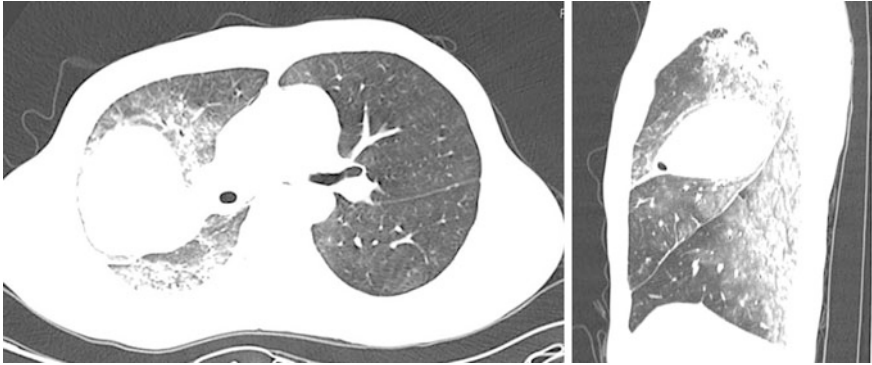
A 41-years-old male patient with blunt chest trauma. Spiral CT scan showed a large intrapulmonary hematoma (*black arrow*)
